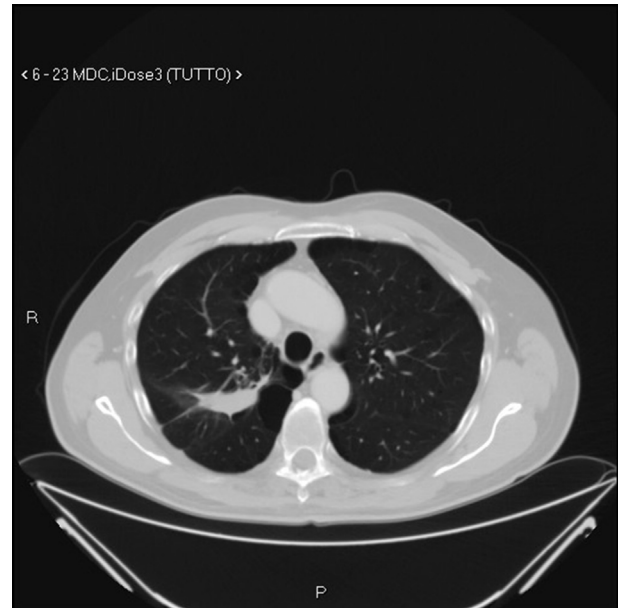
February 4 2020 CT scan.
